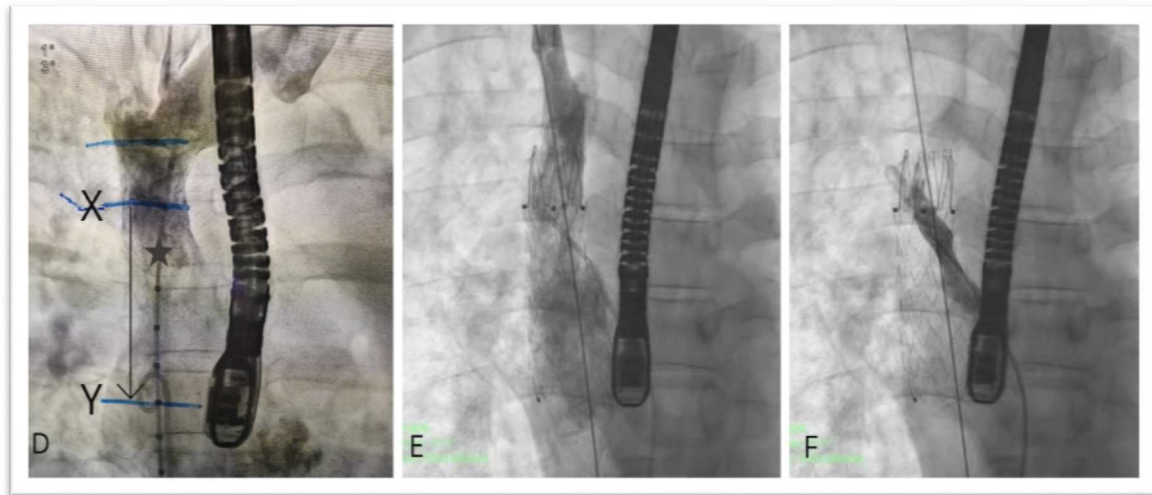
Marker pigtail (solid star) & Normal pigtail simultaneously viewed in fluoroscopy still image after visualizing it in the *trans*-esophageal echocardiography (TEE) and a line is drawn at the beginning of curvature below the pigtail head(Y) kept at lower margin of the defect and it is marked on fluoroscopic still image as the lower end of covered portion of stent. Same pigtail pushed up and line is drawn below the drainage of azygous vein(T3-T4) in the still fluoroscopic as well as TEE image as upper margin of covered portion of stent (X). The distance between points X & Y is the covered portion of the stent(D),(E&F) successful deployment of stent graft and selective right upper pulmonary venography showing unobstructed drainage into the left atrium without any residual shunt across the defect.
